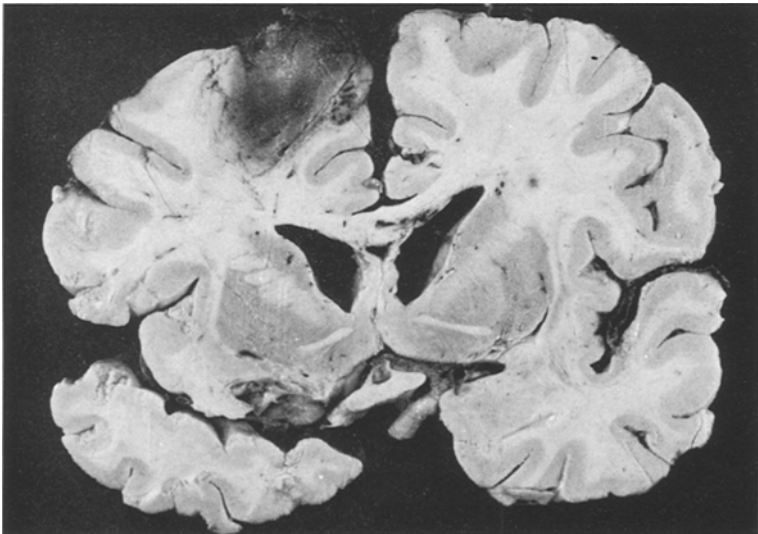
b. Haemorrhagic contusion in the right frontal convexity (not revealed by the CT scan). Haemorrhagic lesions in the corpus callosum
